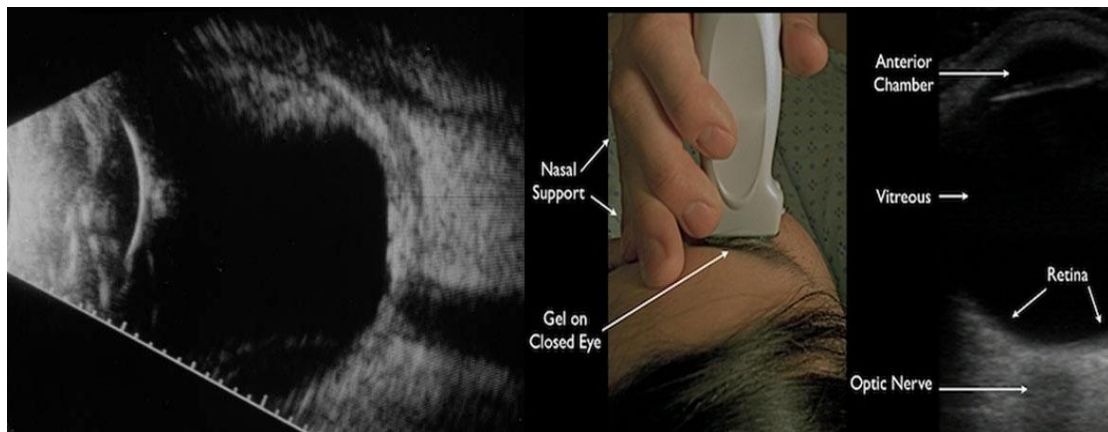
Ocular Imaging or Eye ultrasound or B-scan⁽⁶⁾
